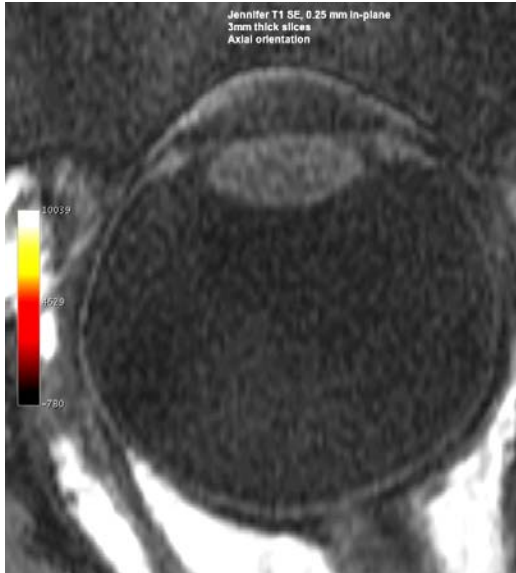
T1-weighted MRI image: using a protocol designed by Professor Krish Singh (CUBRIC, Cardiff University) showing the anatomical detail on a 3mm slice of the authors eye.
